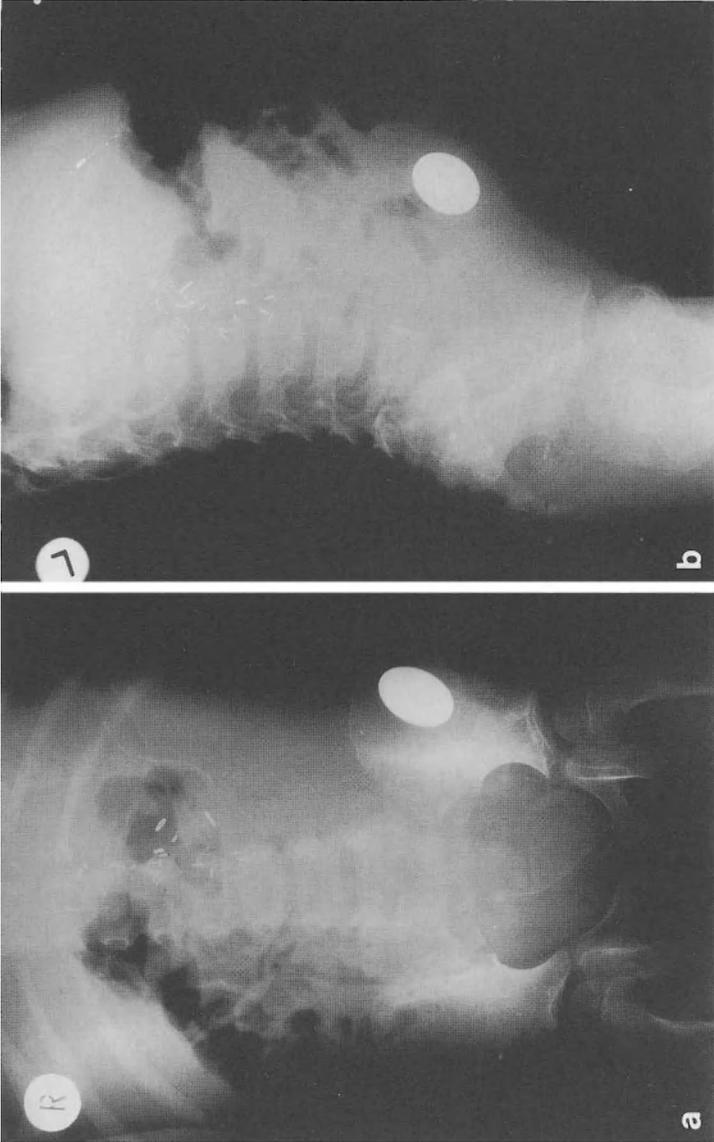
Case 2, a anteroposterior and b lateral plain abdominal radiographs. By means of a puncture the balloon contents were reduced by half following irradiation. The radiographs show the contours of the emptied balloon and the metal filling chamber
